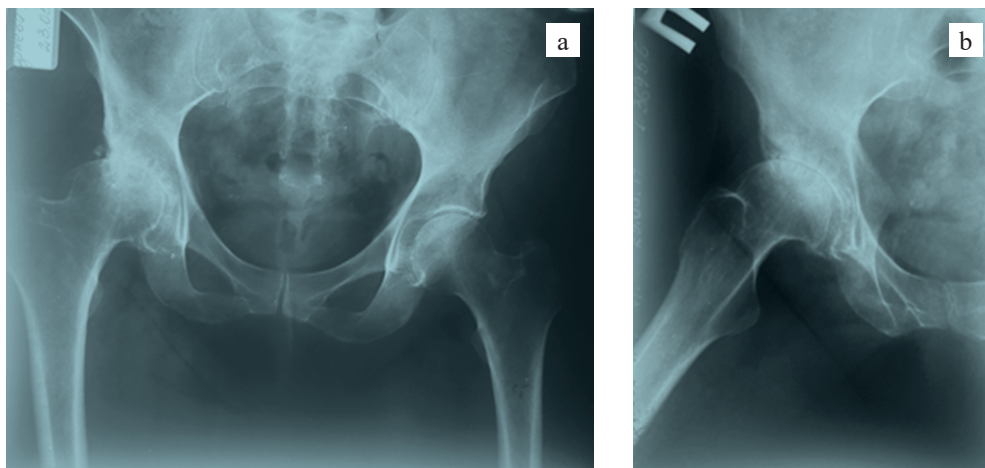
Preoperative X-ray in anteroposterior projection demonstrating FHAN on the right and grade III coxarthrosis: a, general pelvic view; b, image of the right hip joint
